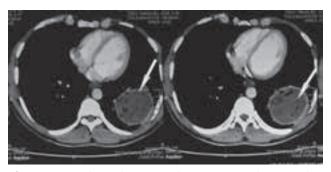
CT chest showing a large cavitary lesion (*white arrow*) in left lower lobe of lung.
